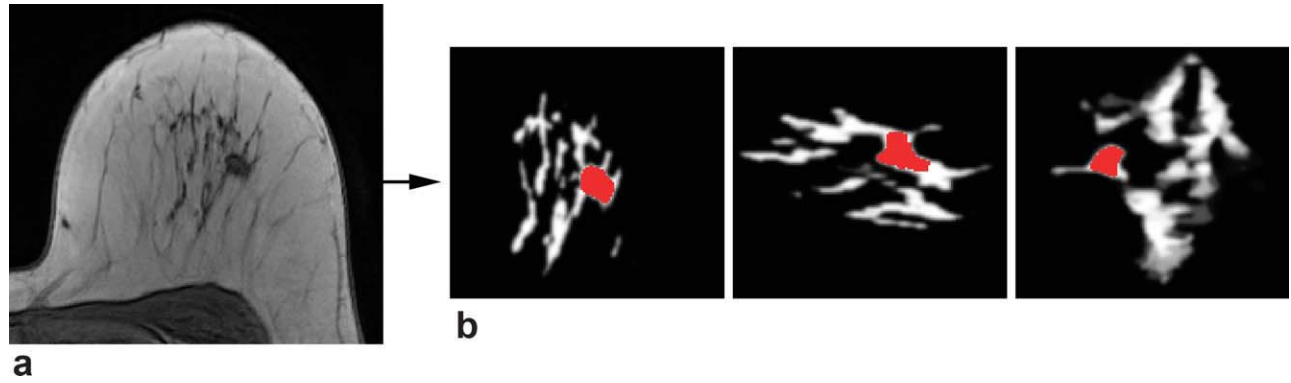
a: A single slice of the anatomical T1w 3D breast MRI scan, in which fat tissue (bright) and glandular tissue (dark) is discernible. From the anatomical dataset, a 3D breast model is computed, containing the distribution of glandular and fat tissue in 3D. b: (parts of) Three orthogonal slices through this breast model, the glandular tissue is depicted bright and fat tissue is shown in black. The tumor tissue is segmented for quantification purposes and shown in red. [Color figure can be viewed in the online issue, which is available at wileyonlinelibrary.com.]
